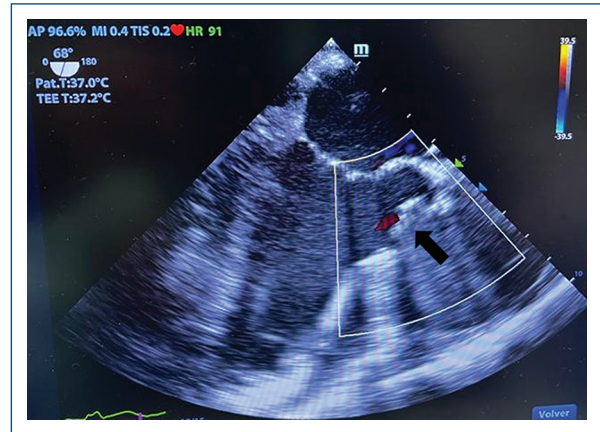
A control echocardiogram showed complete occlusion of the graft at the neck of the pseudoaneurysm (arrow).
